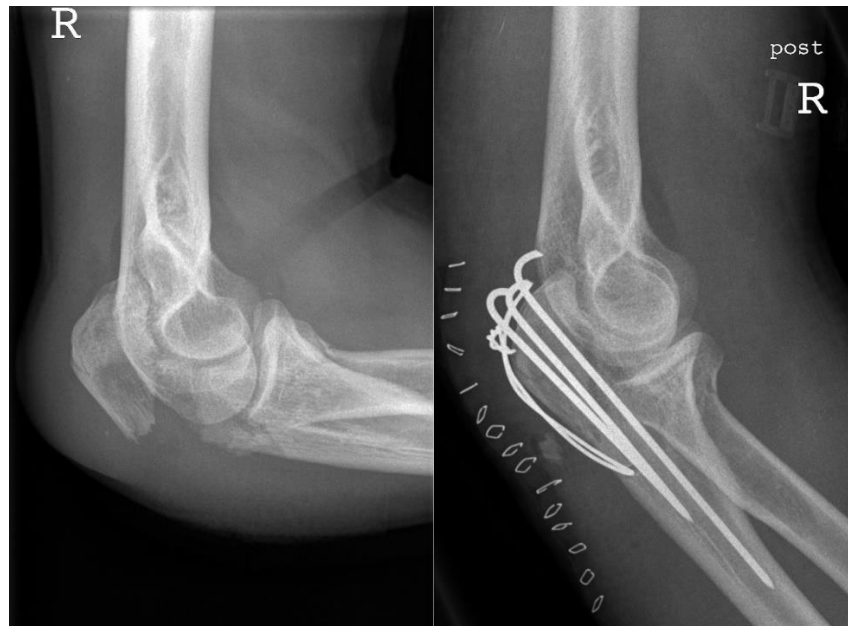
Radiographs of an olecranon process fracture, before and after surgical management (6). By Michael Müller-Hillebrand / CC BY (<https://creativecommons.org/licenses/by/3.0>).
